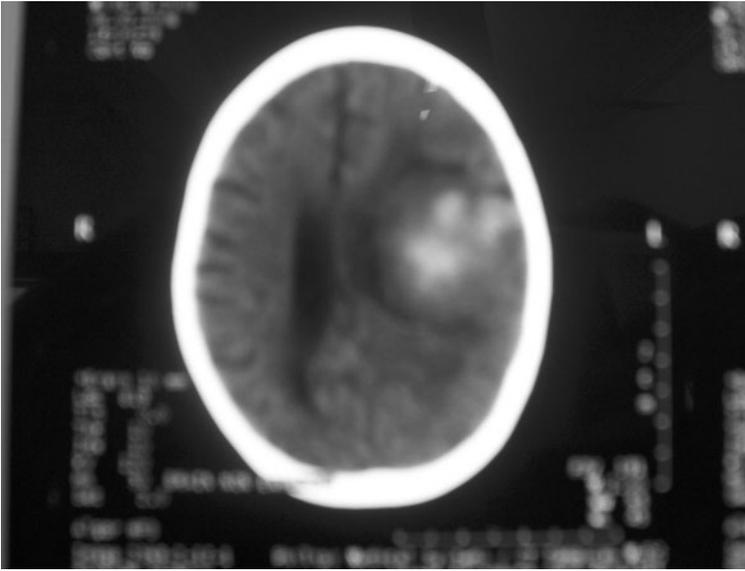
Case 1: CT scan with contrast 1 week after admission showing enhanced lesion in the left temporo-parietal region and midline shift to the right.
